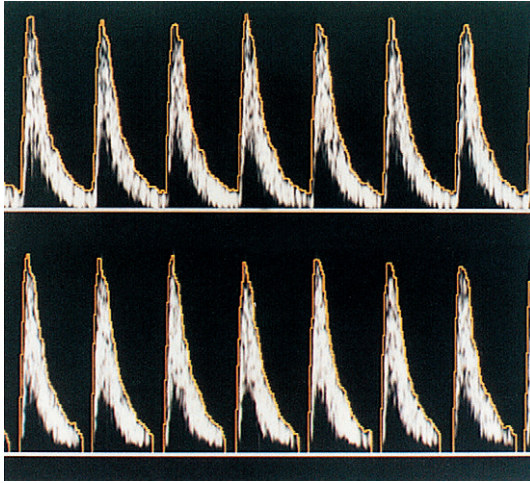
Filtering. Raising the high-pass (wall-thump) filter as in the lower sonogram removes low-velocity signals.
